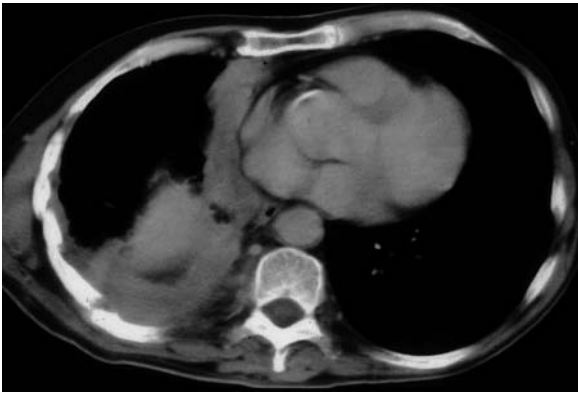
Asbestos exposure in a 56-year-old man with malignant pleural mesothelioma. a Axial non-enhanced computed tomography scan shows concentric nodular pleural thickening. Bilateral calcified pleural plaques are seen (arrows). Note reduction in volume of the affected hemithorax. b Axial enhanced computed tomography scan demonstrates that pleural nodules enhance following contrast administration
